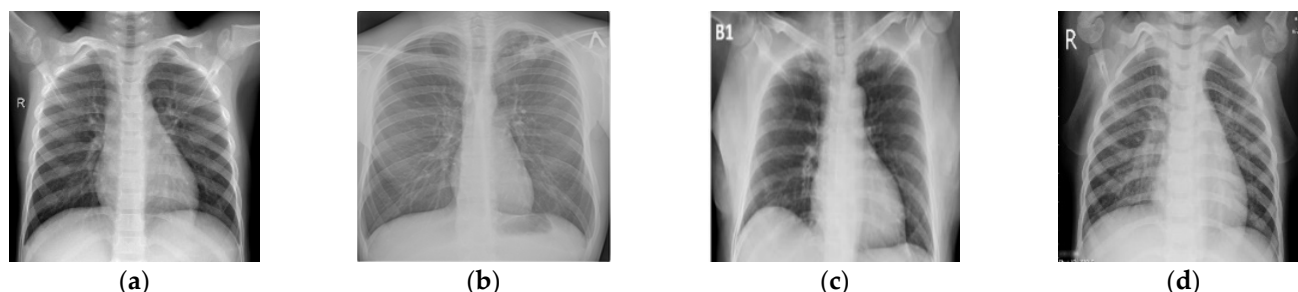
The Samples of X-rays from 4 classes: (a) Normal sample; (b) Tuberculosis sample; (c) Coronavirus sample; (d) Viral-Pneumonia sample.
